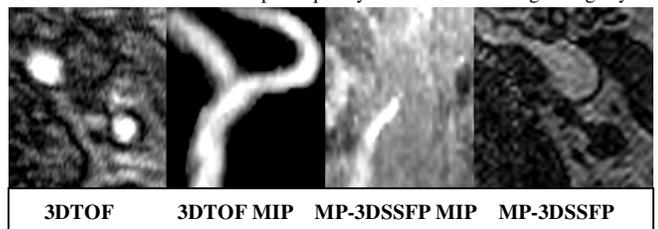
A 65 year-old man with a 50 – 70% internal carotid stenosis on Doppler ultrasound. At left, MIP images from triggered (A) MP-SSFP and (B) 3D TOF . The SSFP MIP is of poor quality. Axial source images slightly distal to the bifurcation from each sequence are shown above.
